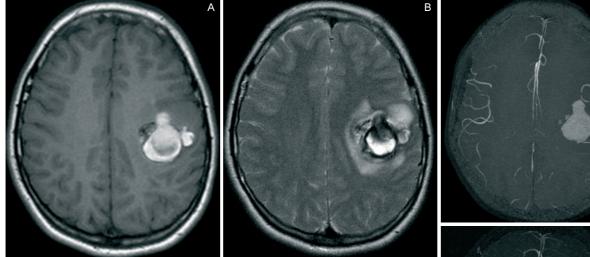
Cavernous angioma (surgically proved). In T1-weighted image (A) the lesion is predominantly hyperintense due to extracellular methemoglobin. In T2-weighted image (B) peripheral hemosiderin is showed. Likewise Figure 4 and 5 cases in conventional MRA (C) the hyperintense tissue overlaps vascular images, while in subtractive MRA (D) blood signal is removed.
